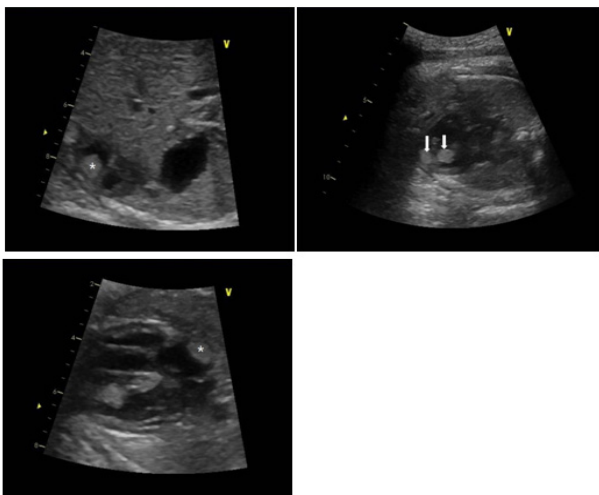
Fetal echocardiogram showing multiple cardiac tumors. (A) A 0.7 cm mass at the apex of right ventricle (asterisk), (B) Two masses with sizes of 0.8 cm and 0.4 cm in the left ventricle (arrows). These masses are attached to the septum and connected to each other. (C) A 0.8 cm mass in the right atrium (asterisk).
